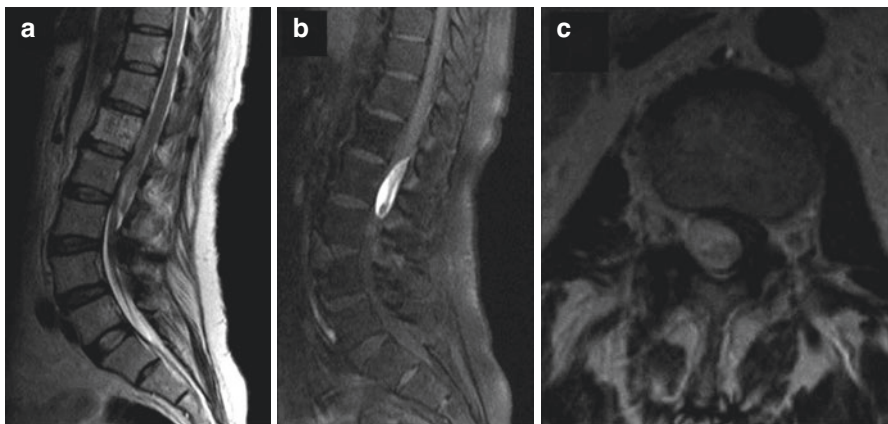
(a) Preoperative images from a sagittal T2-weighted MRI, (b) sagittal T2-weighted FSE MRI, and (c) axial T2-weighted MRI revealed a spinal subdural hematoma at L2. (Reproduced from Kobayashi K et al. *Eur Spine J* (2017)26:2739–43; with permission) [44]
